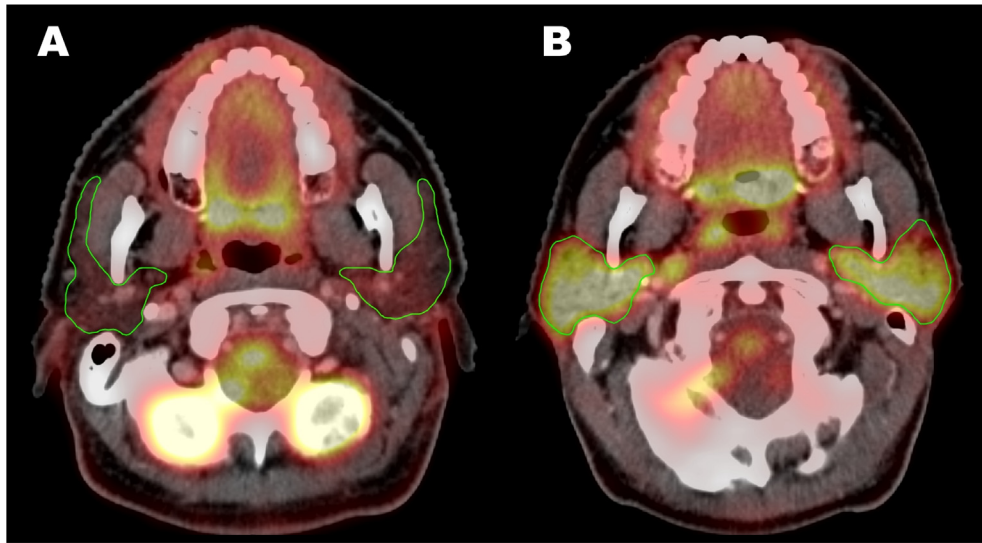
Example of patients with (A) low and (B) high values of mean SUV, P90 and LRHG3E, which were associated with (A) higher and (B) lower risk of developing Xer_{12m}. Scaling in both images: 0.5–3.5 SUV.
